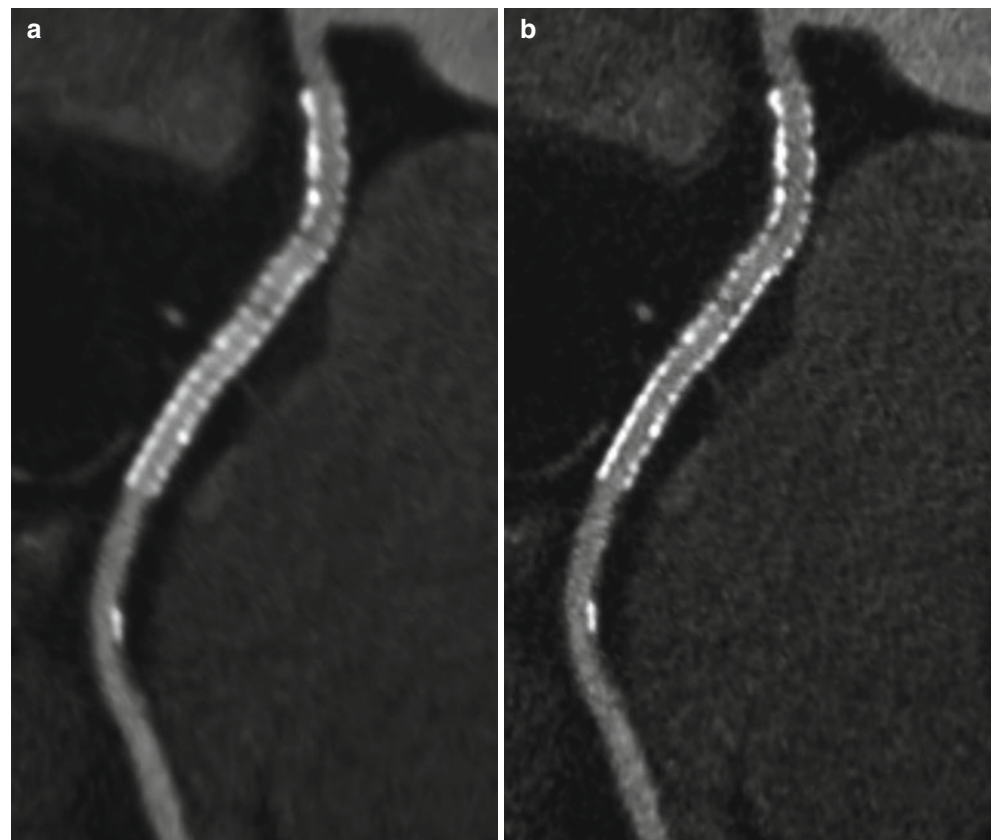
Effect of image reconstruction kernel on image quality. Curved planar CT image of sirolimus-eluting stent (Cypher) with soft reconstruction kernel (B26; Siemens, Definition FLASH CT) (a) and sharp reconstruction kernel (B46) (b). In the sharp kernel image, blooming artifact from stent strut was markedly reduced as compared with that of soft kernel image
